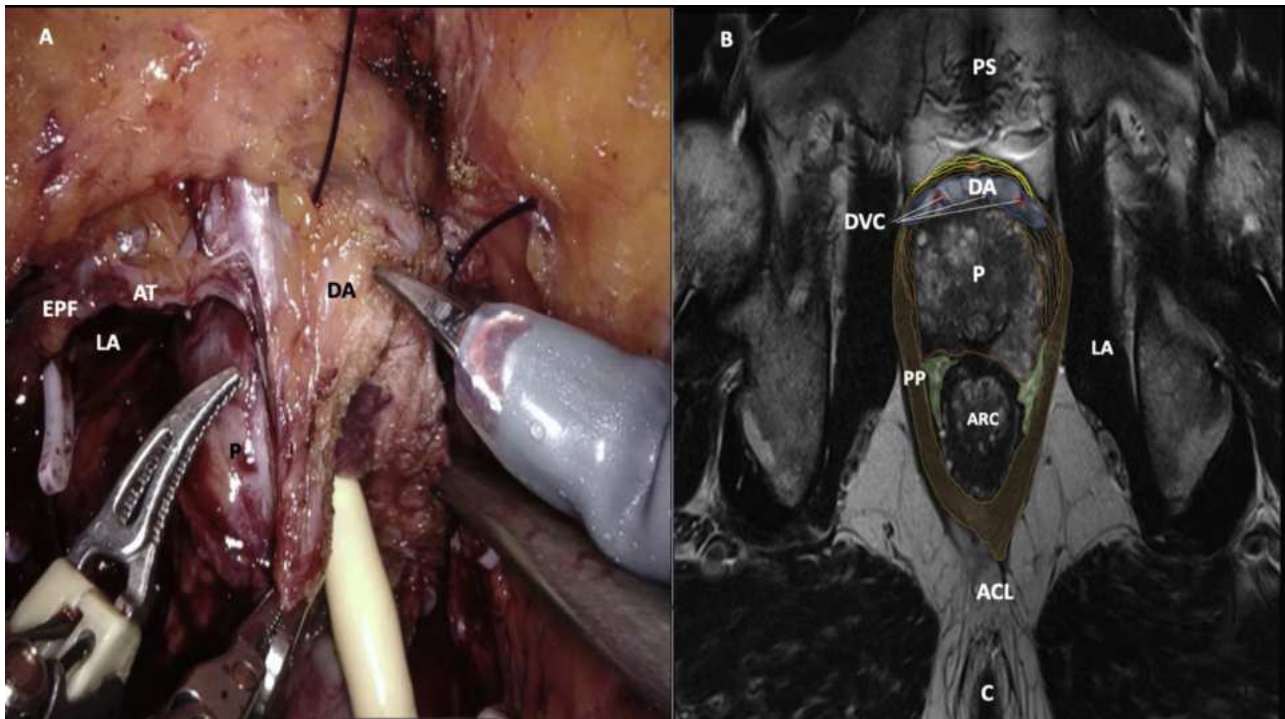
MRI and intraoperative images corresponding to section A. (A) Intraoperative image showing components of the hood. (B) MRI of the pelvis (cross section) corresponding to the intraoperative image. ACL=anococcygeal ligament; ARC=anorectal canal; AT=arcus tendineus; C=coccyx; DA=detrusor apron; DVC=deep venous complex; EPF=endopelvic fascia; LA=levator ani; MRI=magnetic resonance imaging; P=prostate; PP=puboperinealis muscle; PS=pubic symphysis.
